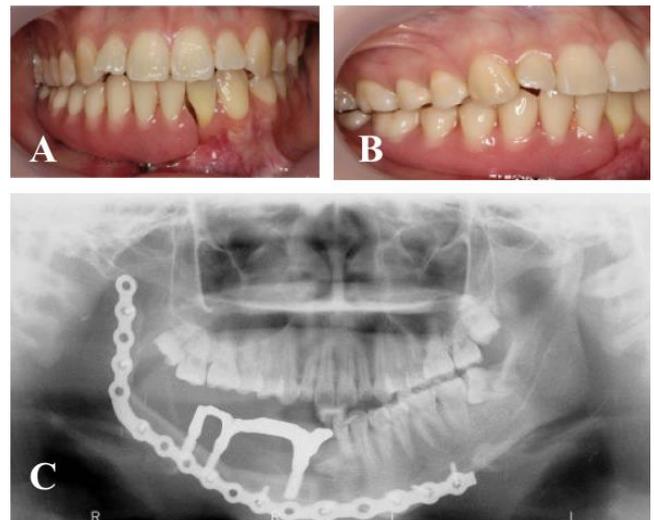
Final definitive prosthesis (A) Frontal view of the bar supported overdenture, (B) Lateral view of the bar supported overdenture, (C) Bar construction radiographically
